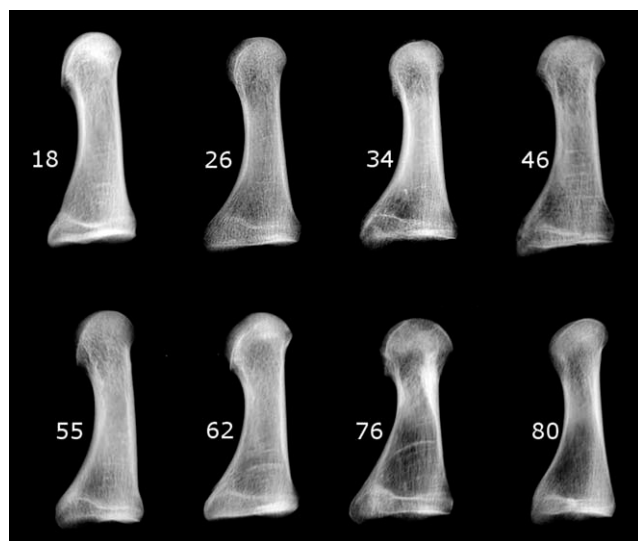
Epiphyseal scar variability. The basal epiphyseal scar is easily detectable in individuals aged 18–80 years from the Hamann-Todd Collection (ages of individuals shown to the left of the metatarsal radiographs).
